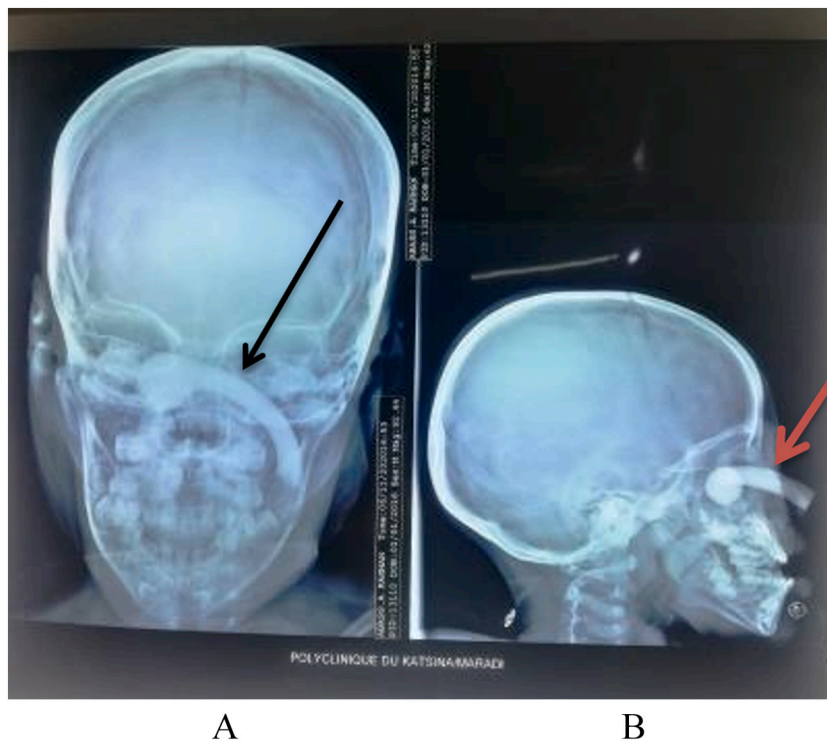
Radiograph of the child's skull, front (A), and side (B), showing the presence of an intra-orbital metallic foreign body (red arrow) with a rounded blunt end in contact with the adjacent orbit (black arrow).
